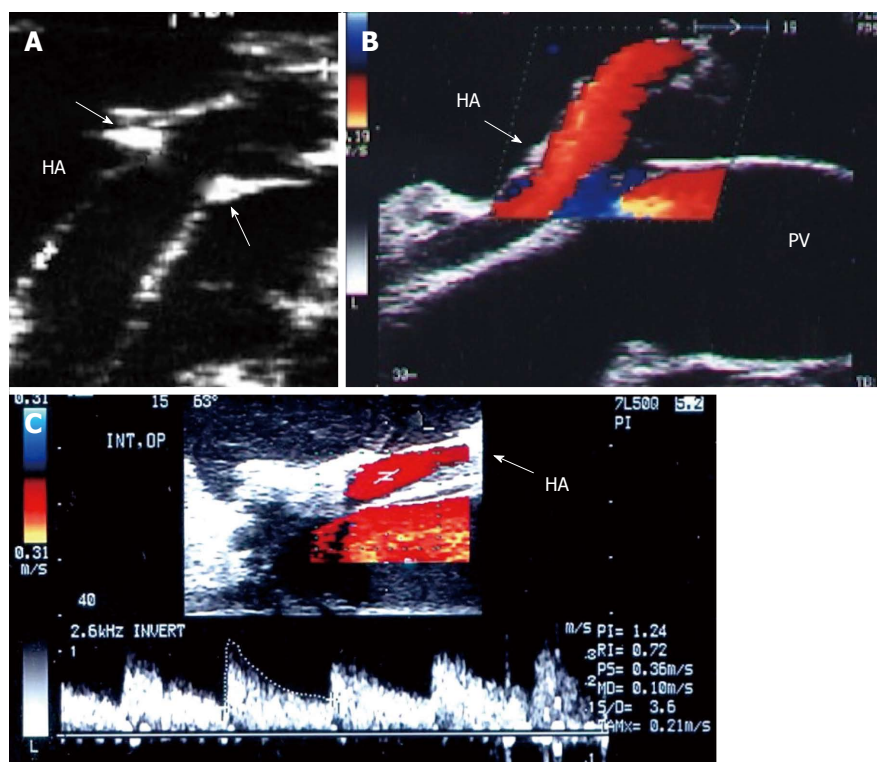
Intra-operative ultrasound evaluation of hepatic artery anastomosis. A: B-mode ultrasound image showing the HA anastomosis, appearing as an echogenic shadows at the site of anastomosis (arrows); B: Color image showing homogeneous color saturation in the HA (arrow); C: Color Doppler image showing normal biphasic waveform of the HA (arrow). PV: Portal vein; HA: Hepatic artery.
